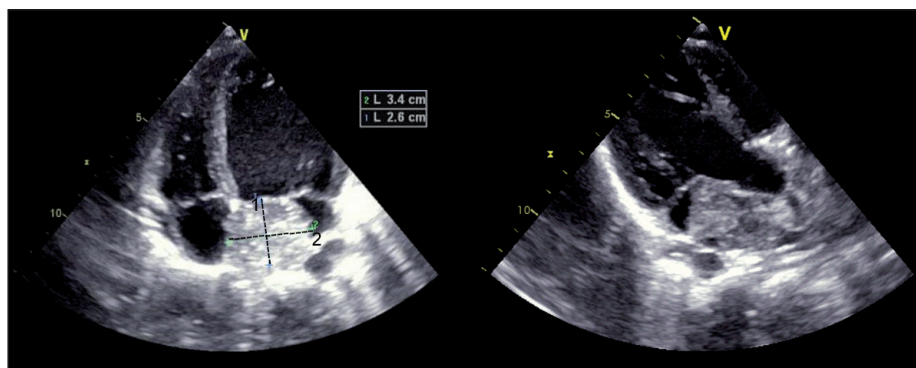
Transthoracic echocardiography showing a left atrial hyperechoic mass of 3.4 × 2.6 cm.
